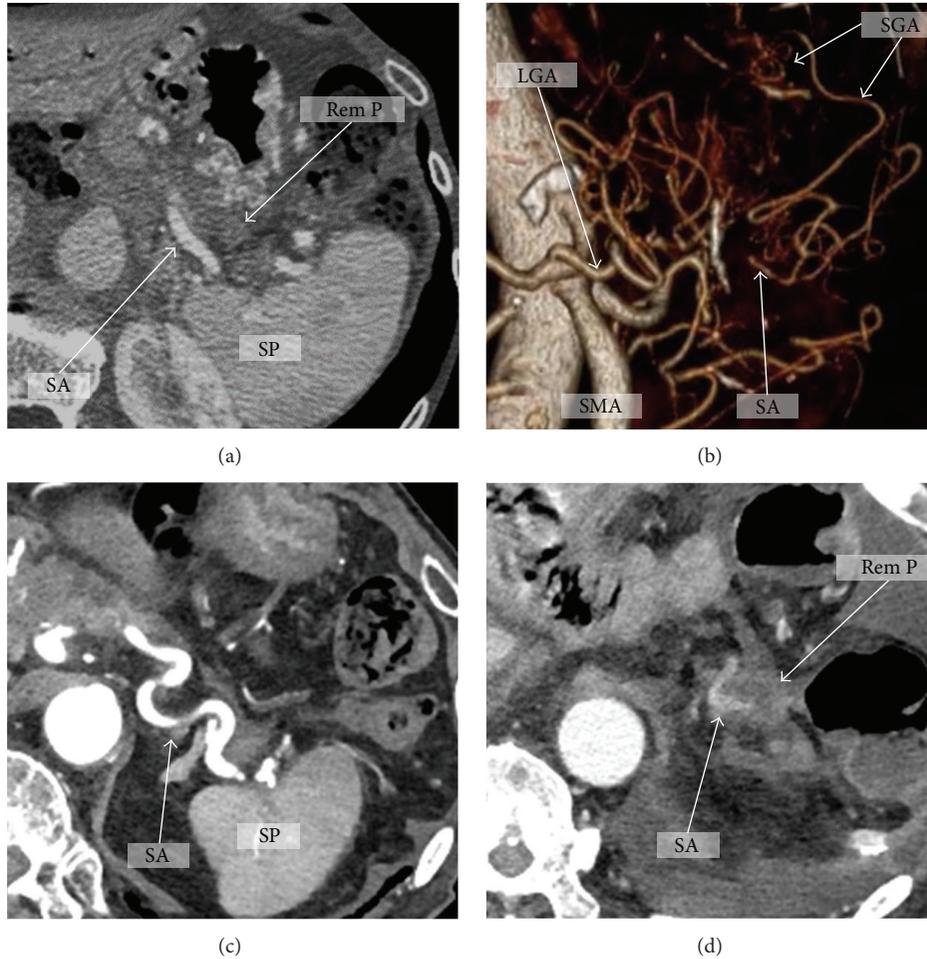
The arterial supply of the remnant pancreas after PD-SAR. MDCT (a) and 3D CT angiography (b) after subtotal stomach preserving PD-SAR showing SA clearly enhanced from SGAs anastomosing with LGA. Pre- (c) and postoperative MDCTs (d) in PD-SAR with total gastrectomy and splenectomy: SA and Rem P are enhanced even after PD-SAR with total gastrectomy and splenectomy, probably from PEA. LGA: left gastric artery. SGA: short gastric artery. SMA: superior mesenteric artery. SA: splenic artery. SP: spleen. Rem P: remnant pancreas. PEA: posterior epiploic artery.
